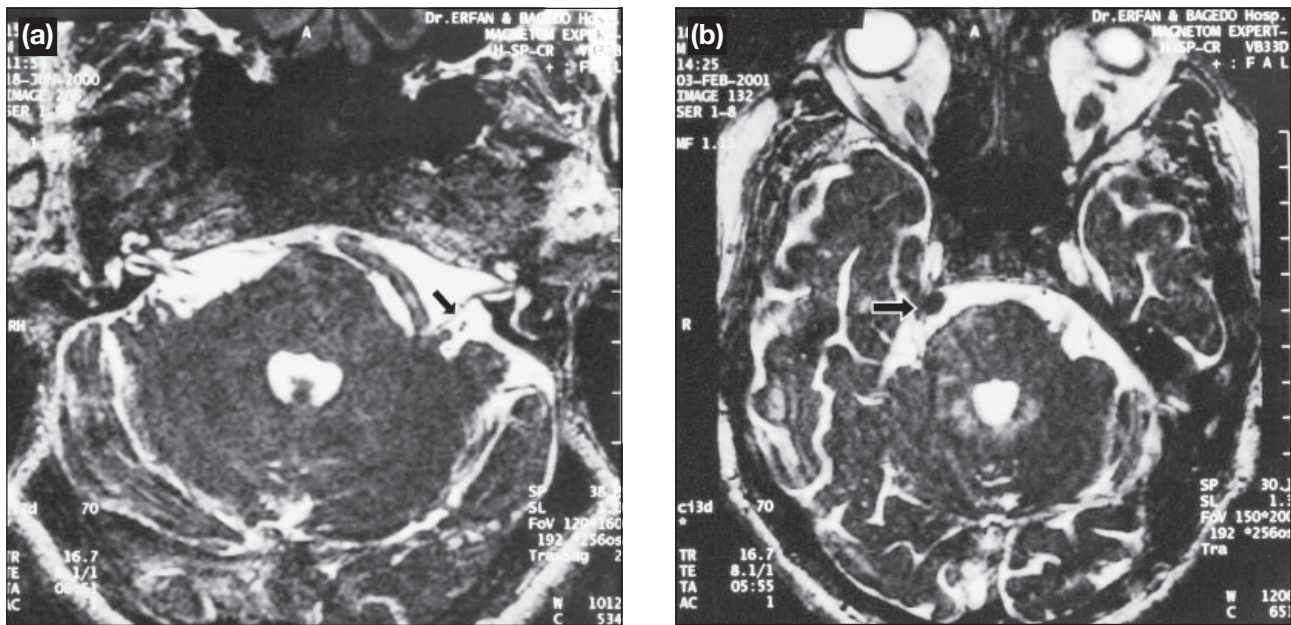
Axial 3-dimensional constructive interference in steady state magnetic resonance imaging scan at the level of the pons shows (a) impingement on the root exit zone of the left facial nerve by a dolichoectatic basilar artery in a patient with left hemifacial spasm (arrow identifies the left facial nerve); and (b) impingement on the right trigeminal nerve by the basilar artery in a patient with right trigeminal neuralgia (arrow identifies the right trigeminal nerve).
